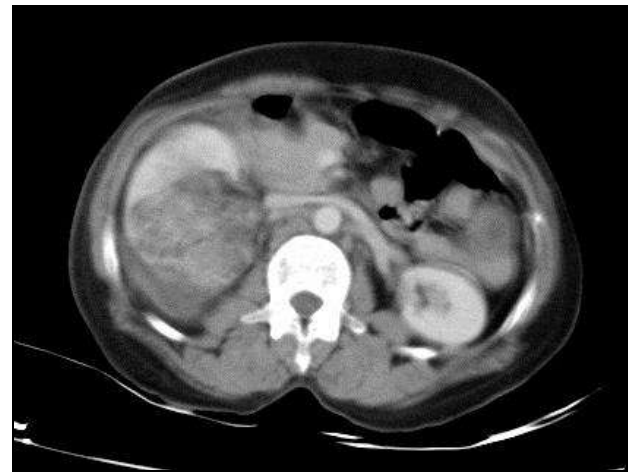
Axial contrast enhanced CT of a 55 yr old man with high speed motor vehicle collision showing avulsion of renal hilum with devascularisation of right kidney-AAST Grade V Renal injury.
